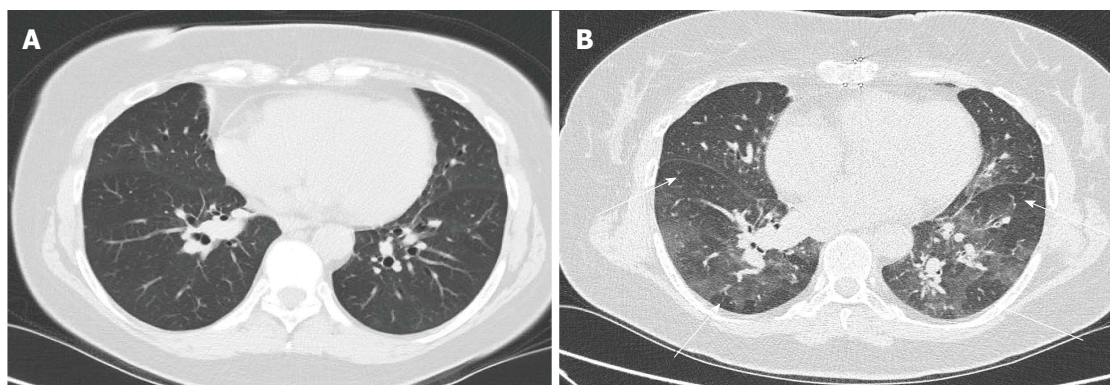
Bronchiolitis/small airway disease. CT scan of the chest performed 8 years post-transplantation shows patchy multifocal air trapping with bronchiolar thickening. A: Axial slice of CT chest image showing bronchiolar thickening; B: Axial slice of CT chest image showing multifocal areas of patchy air trapping. CT: Computerised tomography.
